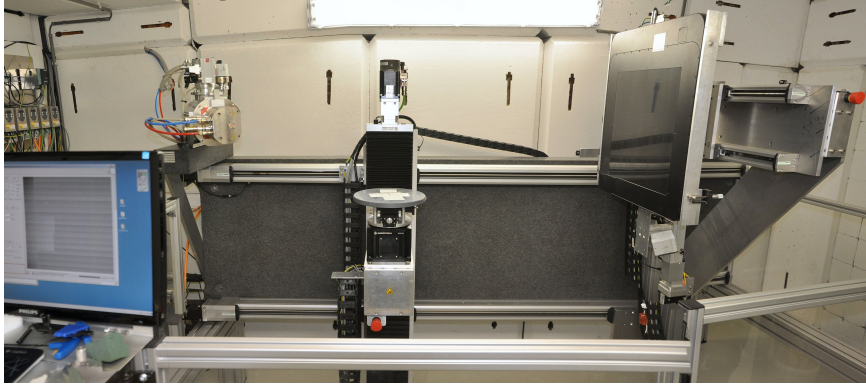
The High-Energy CT system Optimised for Research (HECTOR) at UGCT
